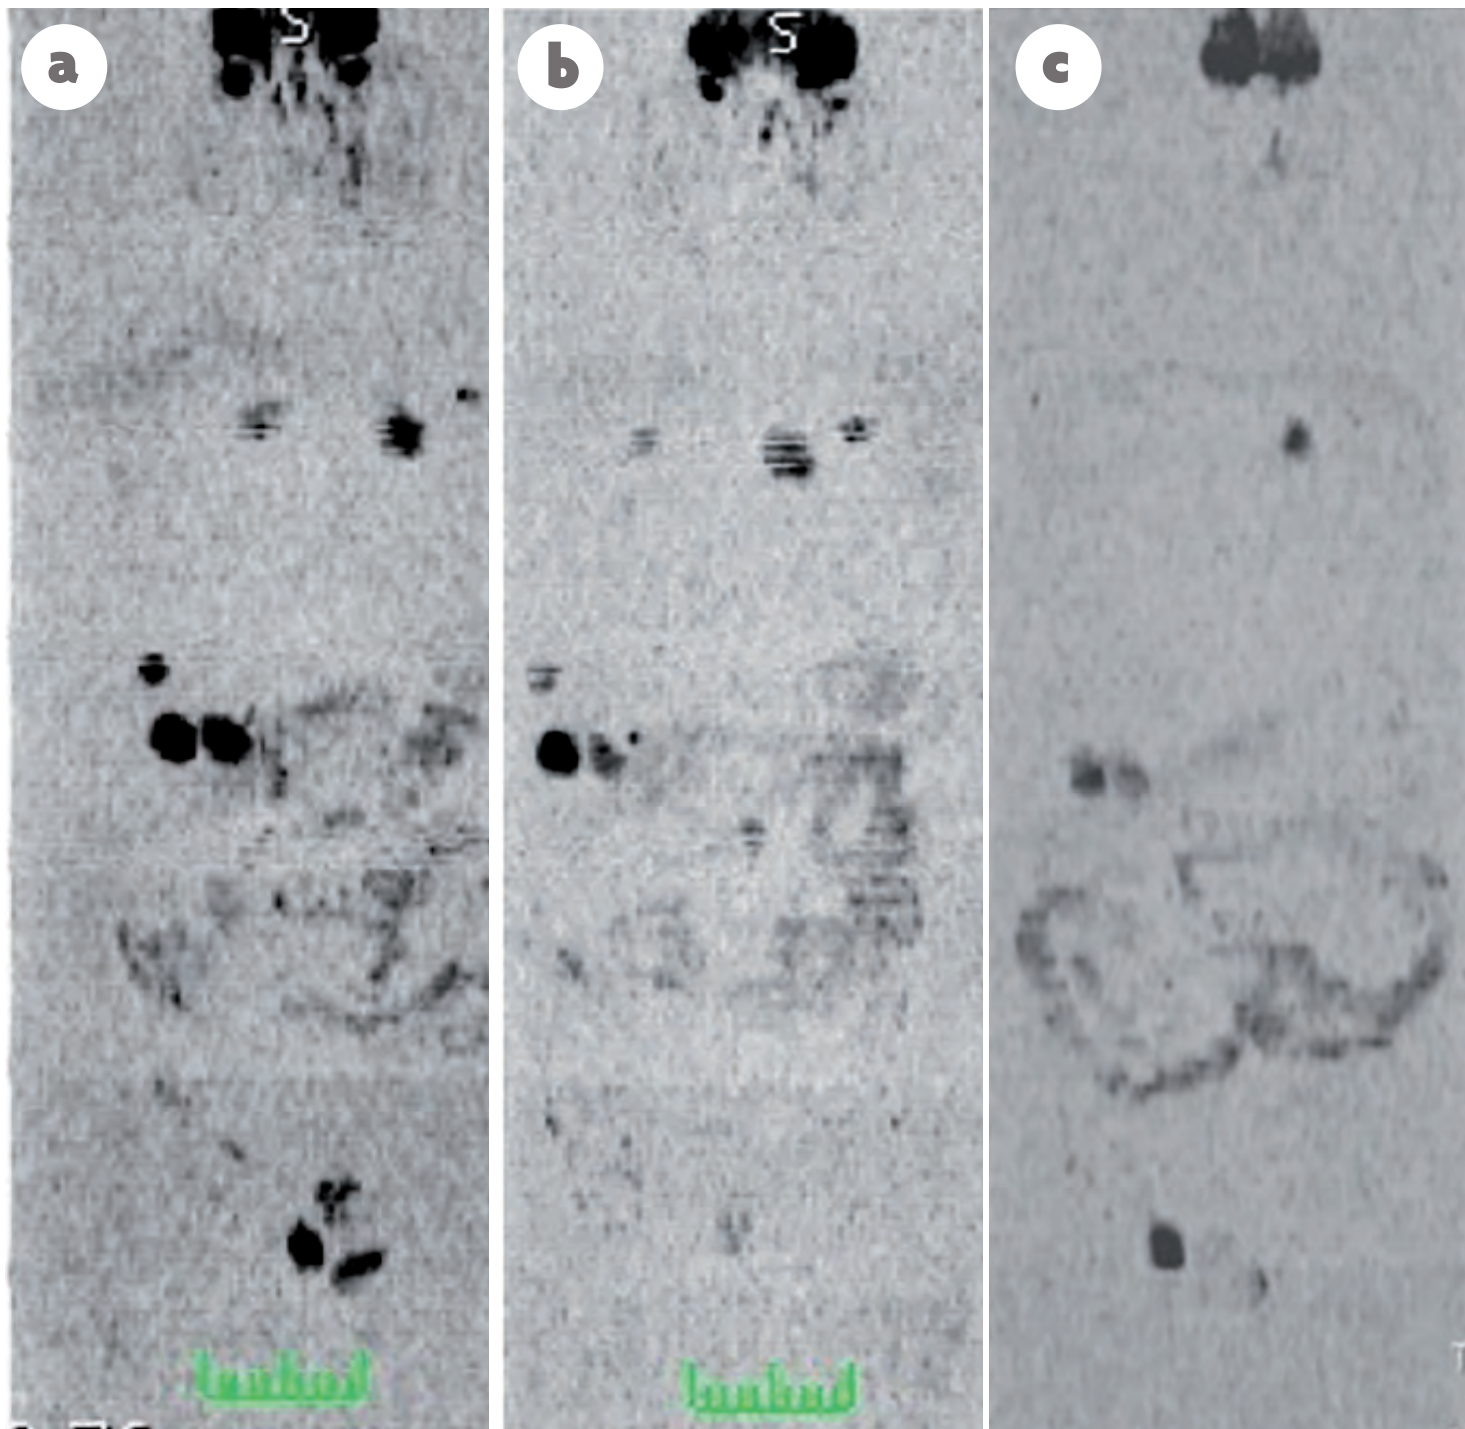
Whole-body coronal MIP grey-scale inverted DWI at 1.5T. (a) Initial exam. Note multiple masses in high signal. (b) After 1 month of chemotherapy: no changes. (c) After 2 months: loss of signal, same size of the masses.
